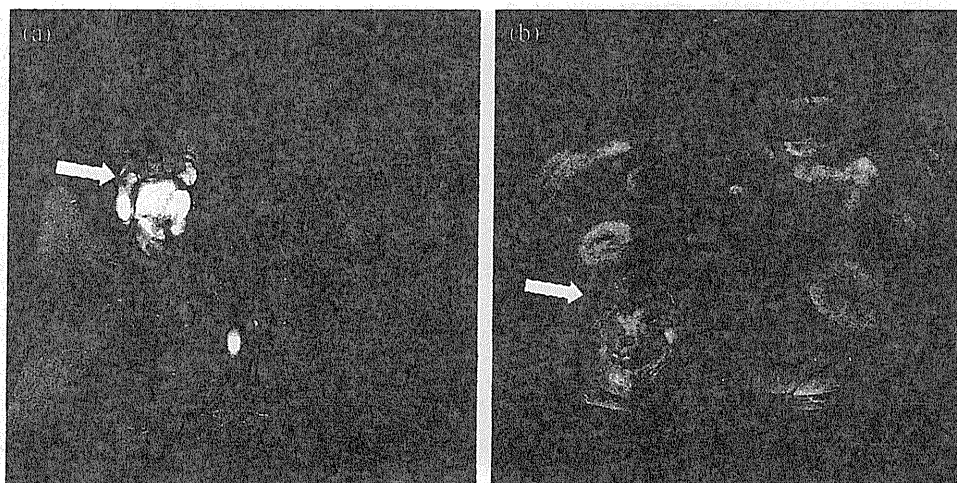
The tumor revealed intermediate to high intensity on T2-weighted image (a) and enhancement on contrast-enhanced T1-weighted image before carbon ion radiotherapy (b).
